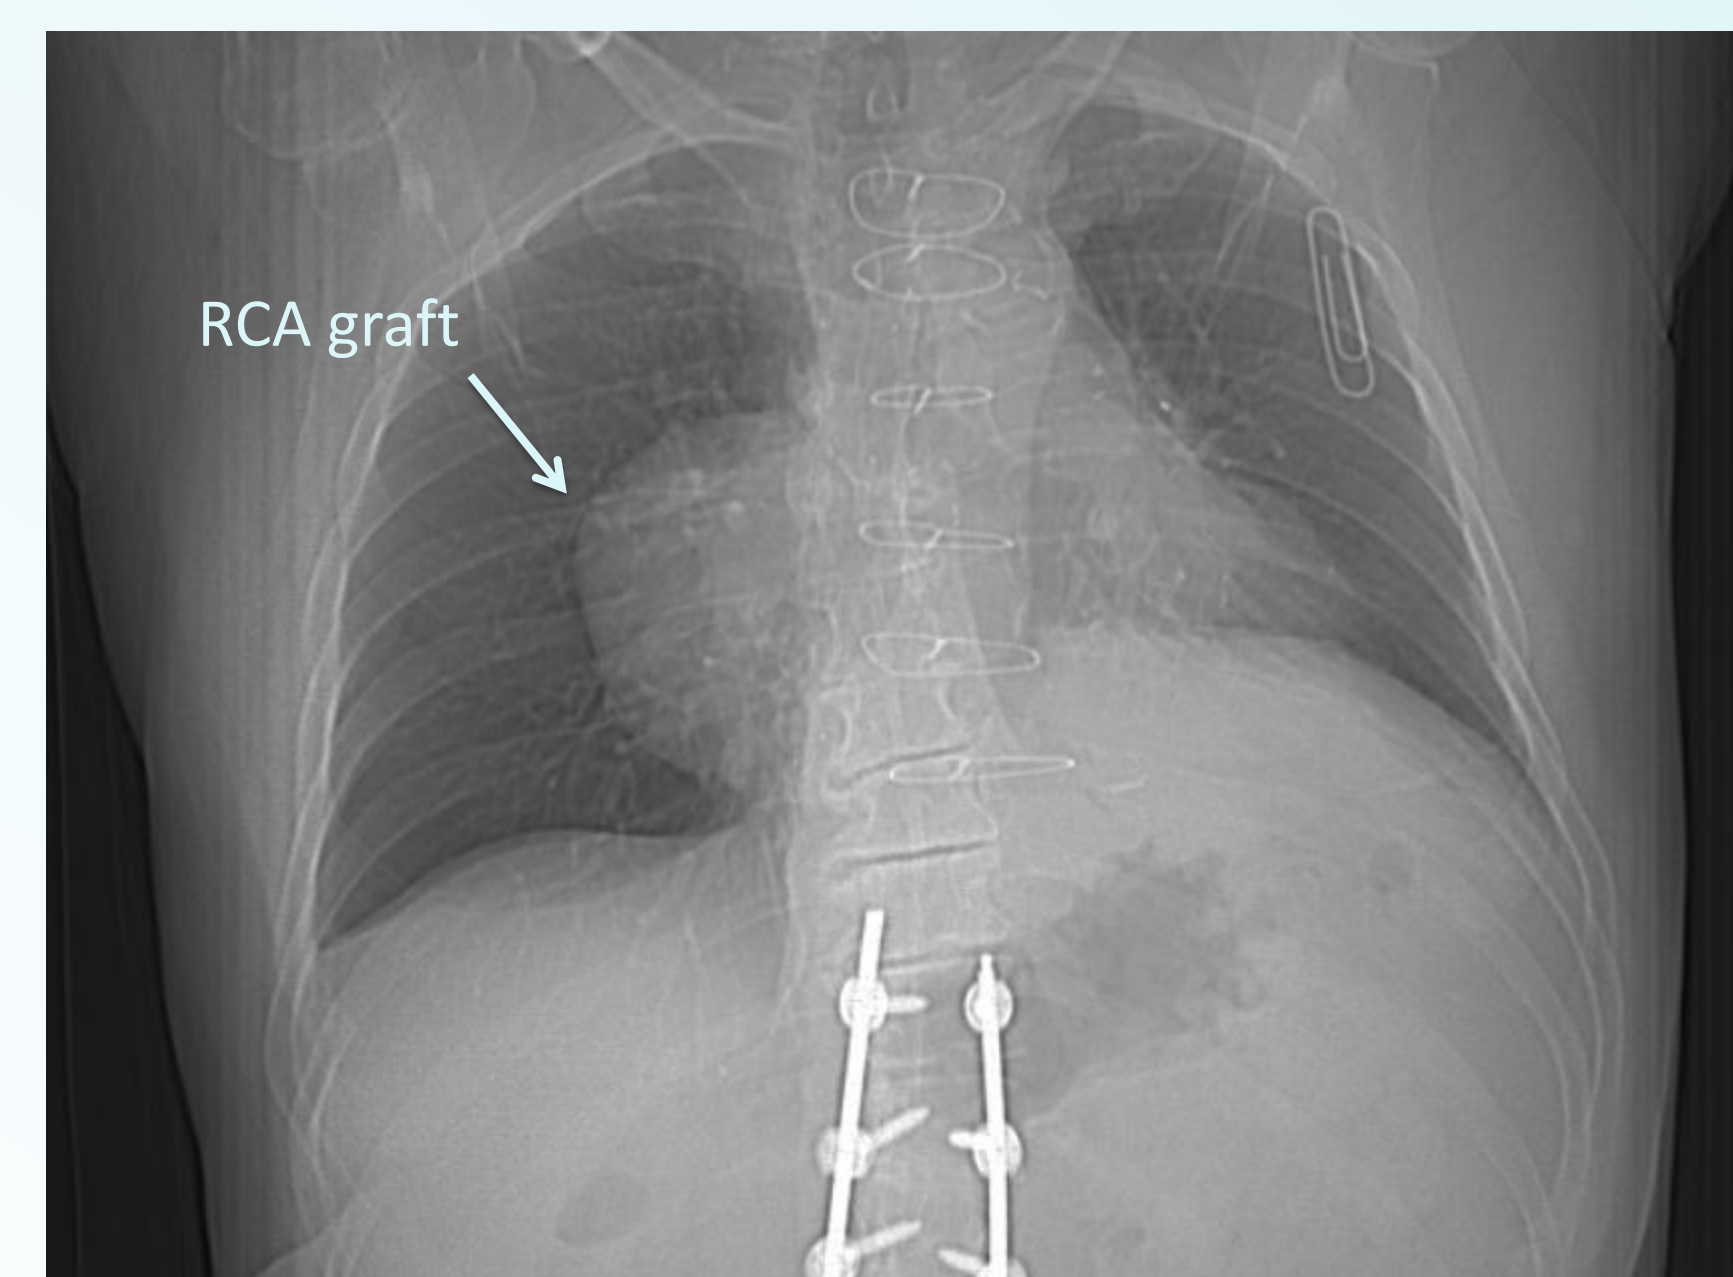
Chest x-ray of patient with evident aneurysmal bulge of RCA
